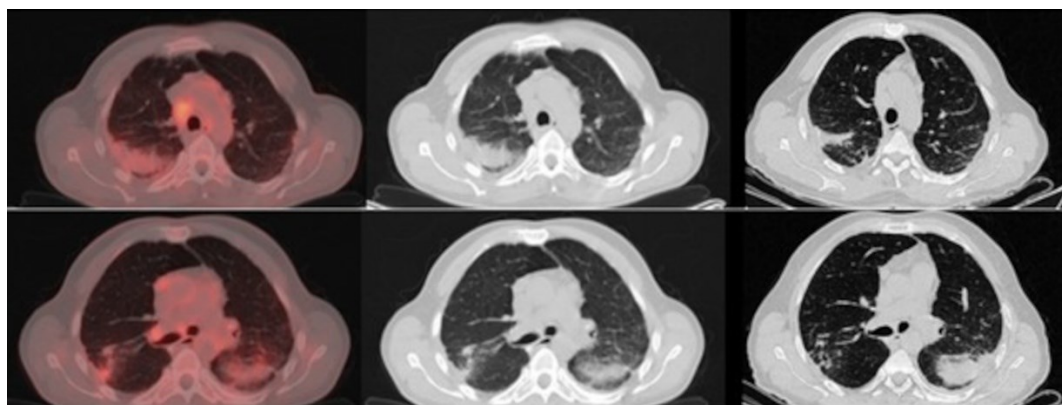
[¹⁸F]FDG PET/CT and HRCT images evaluation of pulmonary parenchymal changes. From left to right: axial fused [¹⁸F]FDG PET/CT, low-dose CT, and corresponding HRCT images demonstrate peripherally located metabolically active fibroreticular consolidations in the bilateral lungs
